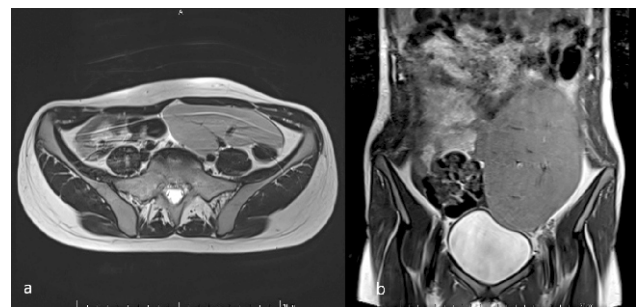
and 1B. Axial (1A) and coronal (1B) T2-weighted images; localized in the left iliac fossa, the hilum was 180 degrees rotation opposite to normal (posterolateral ectopic spleen)
